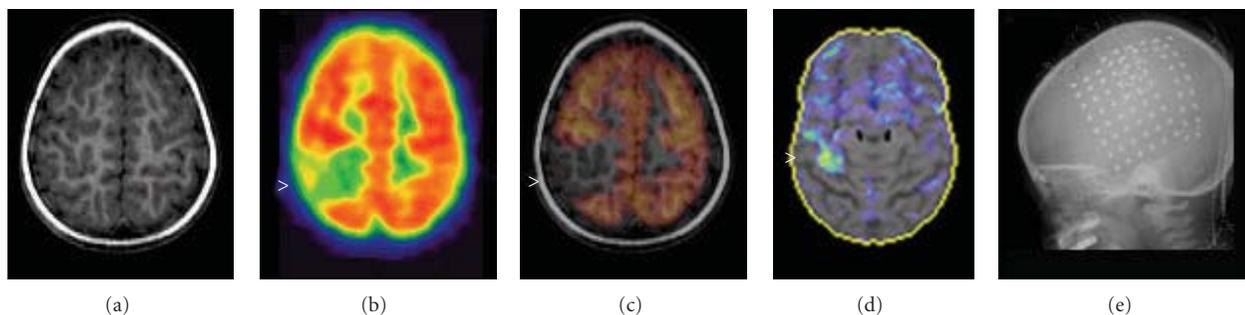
Two-year-old female with intractable partial epilepsy and developmental delay. (a) MRI is normal. (b) Focal F-18 FDG reduction in the right superior parietal lobe representing the epileptogenic focus (arrowhead). (c) MR-PET fusion image. Focal FDG reduction in the right superior parietal lobe representing the epileptogenic focus (arrowhead). (d) 3D-SSP map shows significant reduction of F-18 FDG (arrowhead). (e) Placement of intracranial electrodes guided by F-18 FDG PET is shown on skull radiograph.
